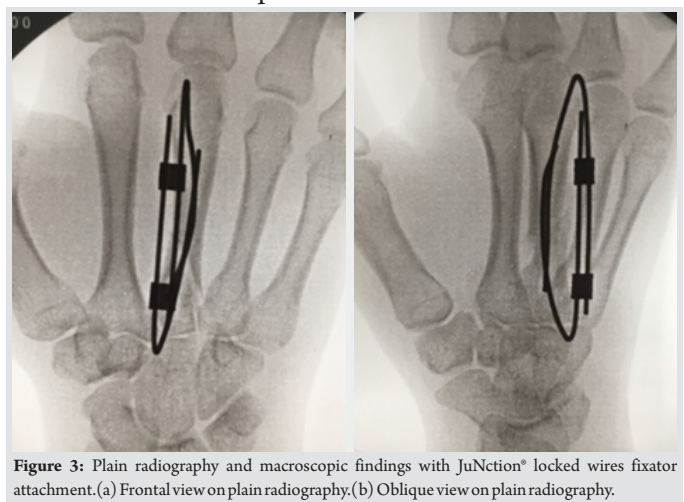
Plain radiography and macroscopic findings with JuNction® locked wires fixator attachment. (a) Frontal view on plain radiography. (b) Oblique view on plain radiography.
